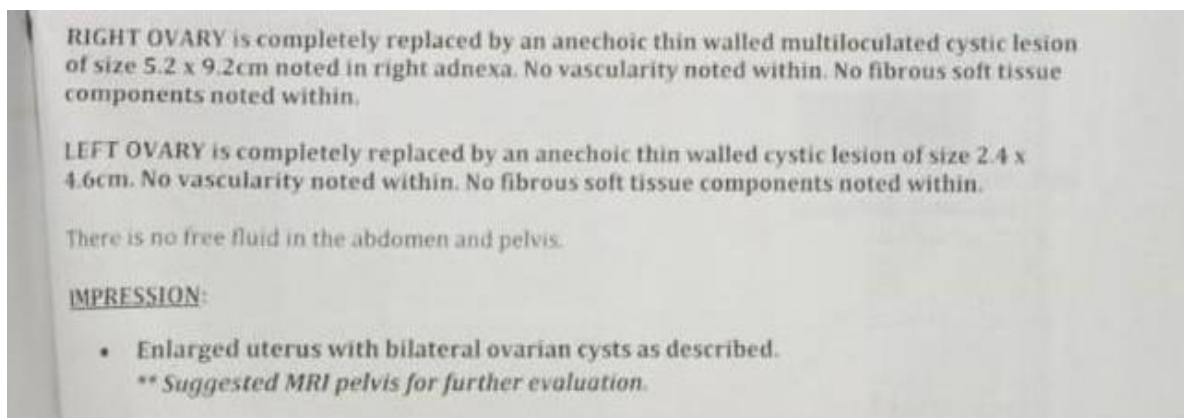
Ultrasound Report
